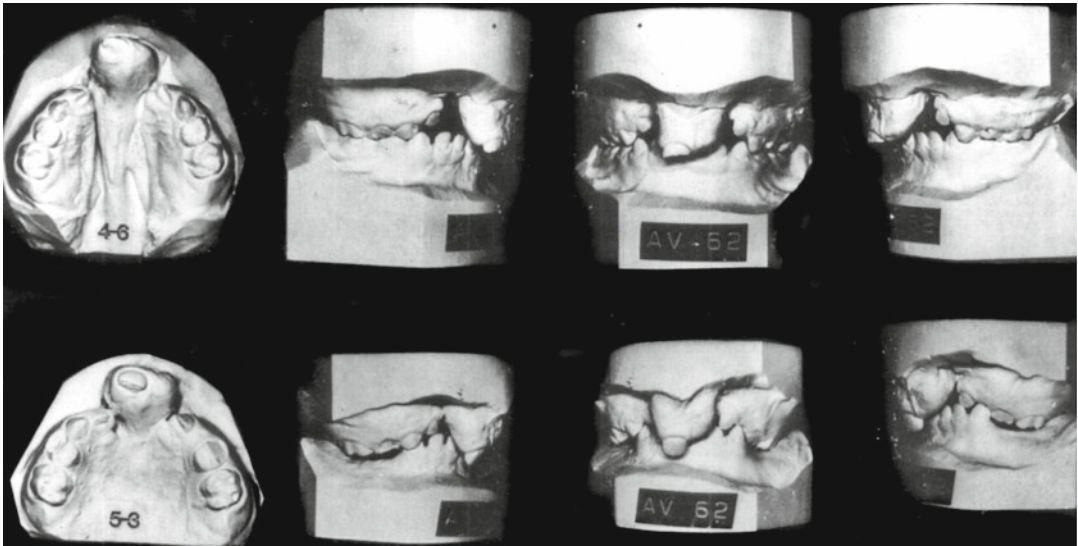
Case CT (AV-62) demonstrates a severe premaxillary overjet leading to a retruded midface and the successful use of protraction orthopedics. This patient was adopted from Central American parents. 4-6 It is
